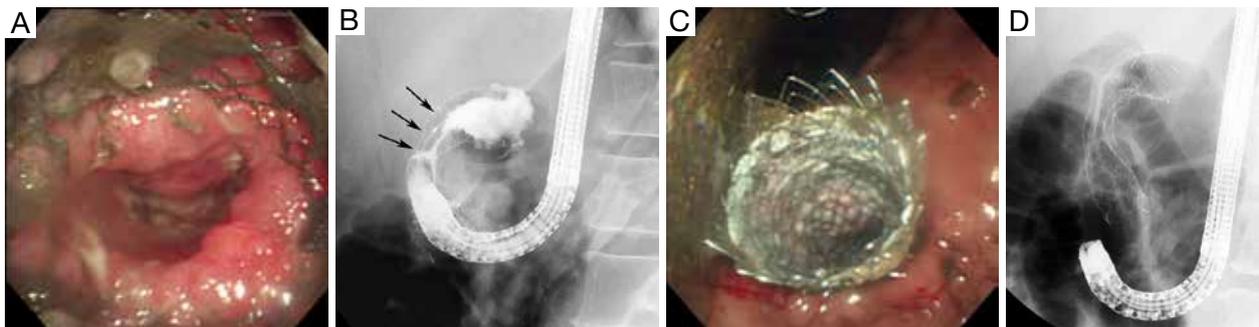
Placement of a second stent for occluded pre-existing SEMS due to tumor ingrowth. (A) Endoscopy reveals stent occlusion due to tumor ingrowth; (B) contrast study using endoscopy showing tumor ingrowth (arrows); (C) a covered SEMS was placed within the occluded uncovered SEMS; (D) radiograph immediate after deployment showing two overlapping SEMSs and the waist of the second SEMS. SEMS, self-expandable metallic stent.
